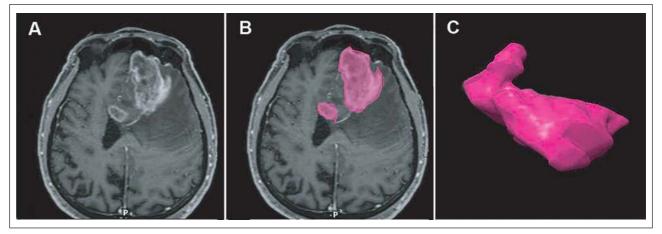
Quantification of the preoperative tumour volume in malignant gliomas. (A) Axial T1-weighted MRI scan of a patient with a left frontal glioblastoma. (B) The contrast-enhancing part of each section is outlined and subsequently fused to generate (C) a 3-dimensional segment which can be quantified volumetrically.
